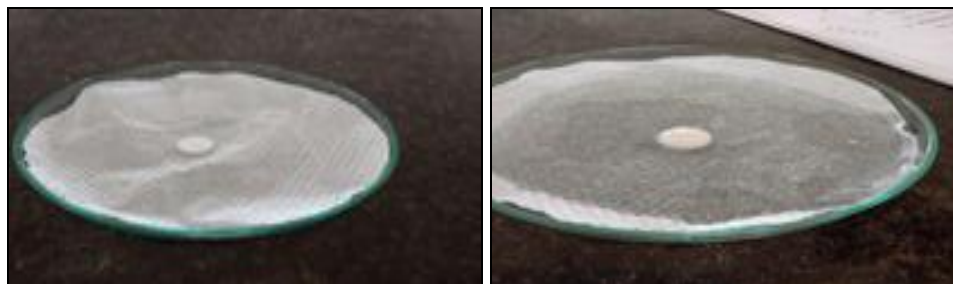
& FIG. 5: REPRESENTS THE WETTING TIME AT 0 SEC AND 10SEC RESPECTIVELY
